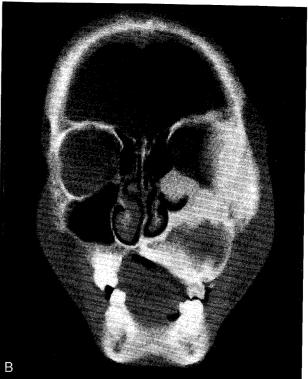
Computed tomographic scans 4 years after first resection. (A, B) There is extensive recurrence of fibrous dysplasia, which has invaded and replaced the previous rib grafts (arrow). (C) A large soft-tissue lesion is demonstrated in the region of the pituitary fossa, which was found to be a pituitary adenoma on operation.
